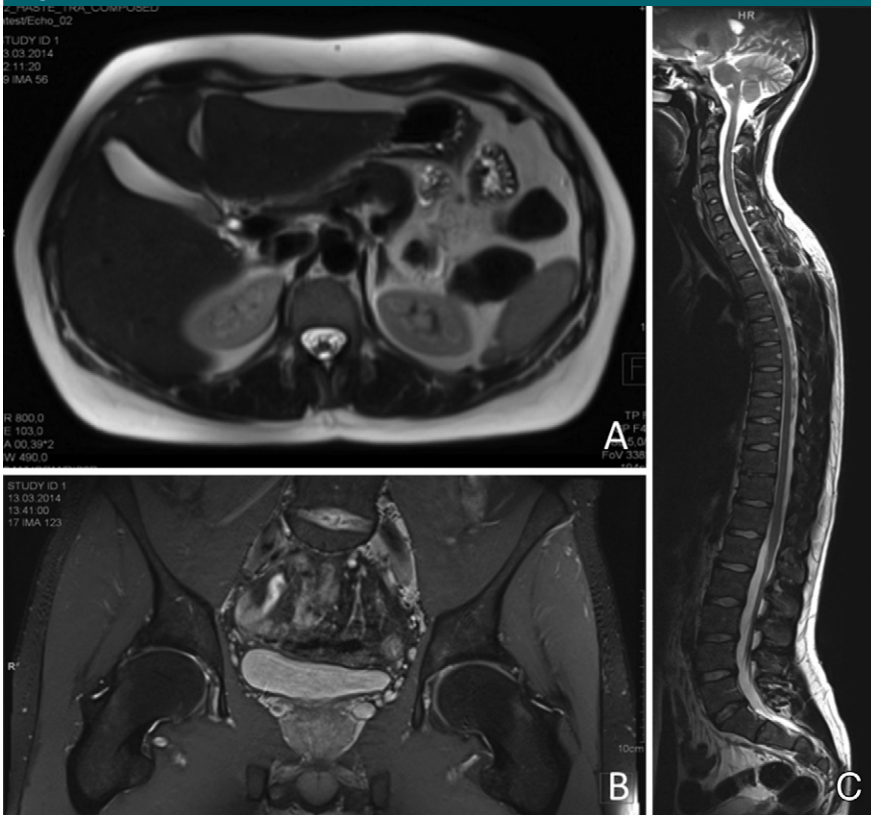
A*, T2-weighted MR image of the thorax and abdomen obtained as part of the body protocol. *B, C*, MR images obtained as part of the musculoskeletal protocol (PD with fat saturation of the pelvis [*B*] and T2-weighted image of the entire spine [*C*]).
